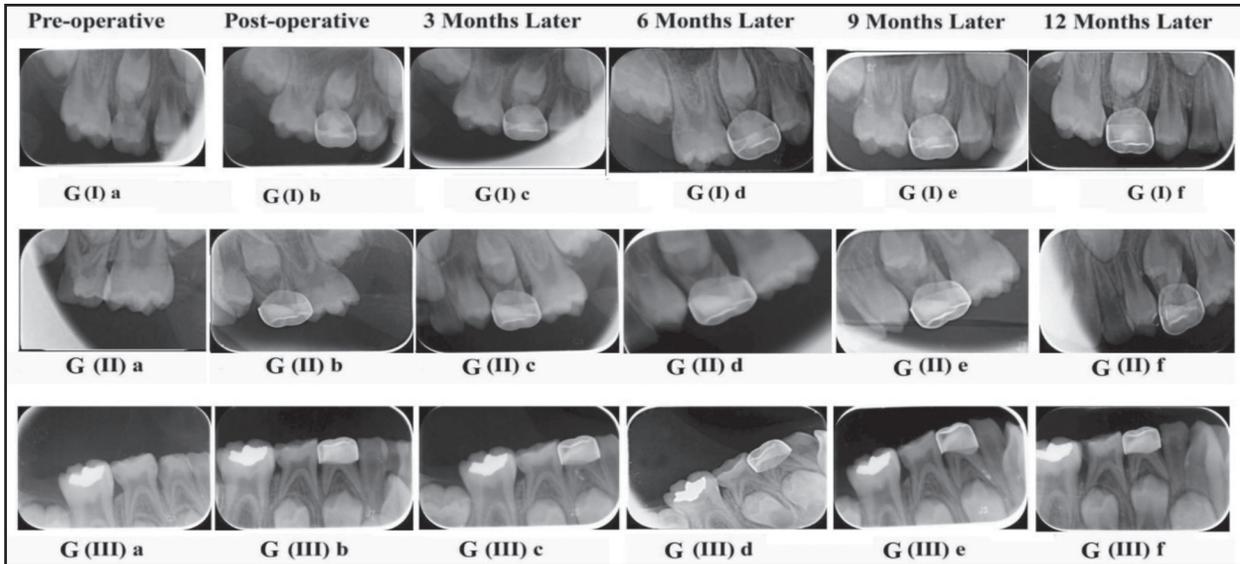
Radiographic showing Biodentine pulpotomy on upper right E (GI), Simvastatin pulpotomy on upper left E (GII), and combination of Biodentine and Simvastatin pulpotomy on lower right D (GIII) at different evaluation period.
